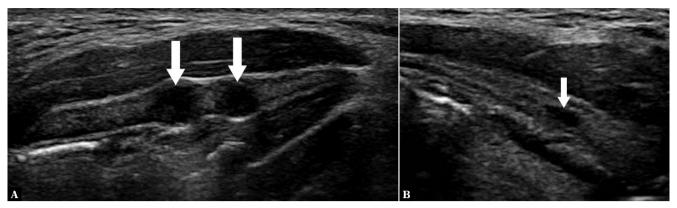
Sagittal ultrasound images of the neck demonstrating hypoechoic well-defined structures in the lamina of the thyroid cartilage (arrows)
